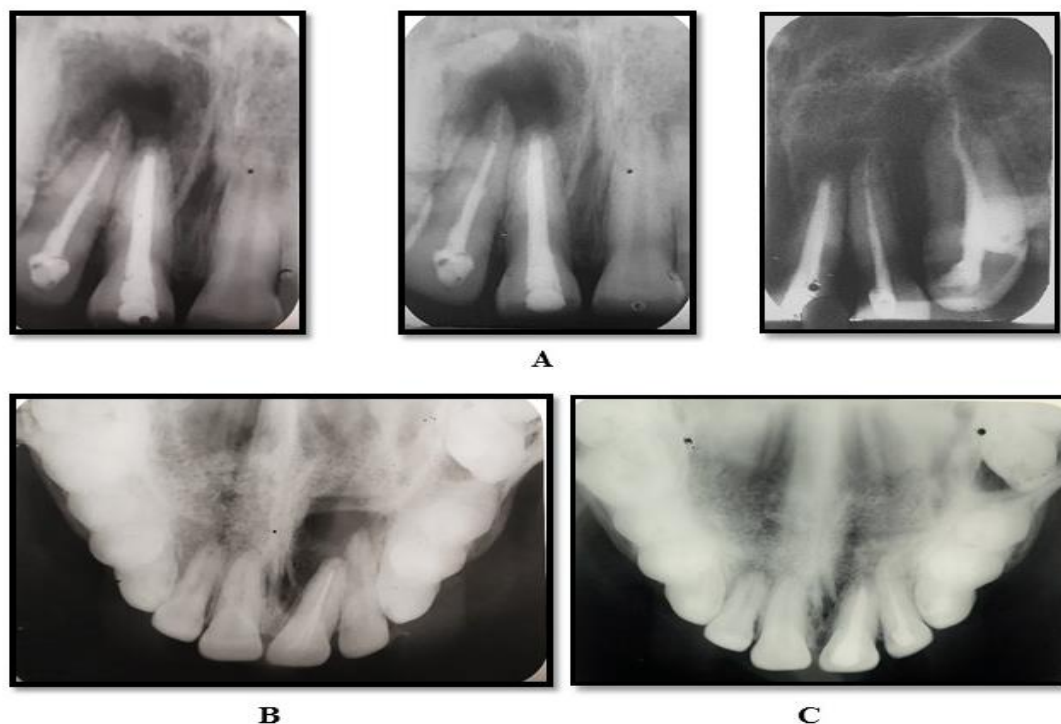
A) 3,6 and 9 months follow-up IOPA; B) Pre-operative Occlusal radiograph and C) 9 months follow up Occlusal radiographs
